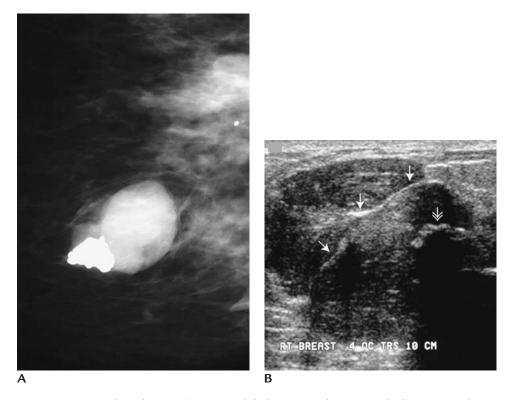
Fibroadenoma. (A) Dense, lobular mass with circumscribed margins and a dense, coarse ("popcorn" type) calcification. (B) Irregular hypoechoic mass with circumscribed, macrolobulated margins is imaged corresponding to the mammographic finding. Hyperechoic (fibrous) bands (*arrows*) are present in the mass. The coarse calcification (*double headed arrow*) is imaged as a thick irregular hyperechoic band with associated dense shadowing. The benign diagnosis of this finding is established mammographically such that an ultrasound, although included out of interest, is not indicated in these patients.
